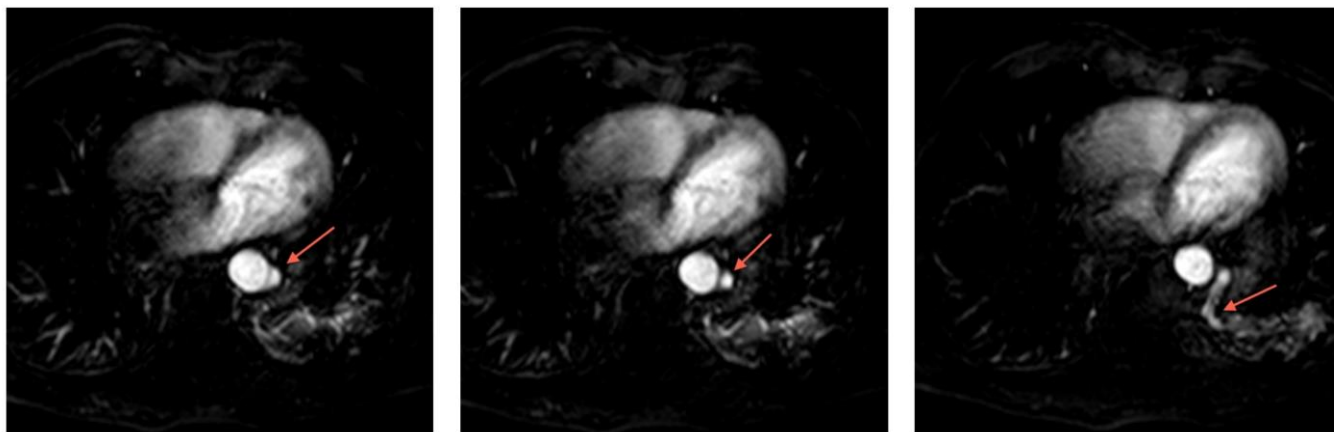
60 year old male with left lower lobe pulmonary sequestration. Findings: T1-post contrast axial MRI images demonstrate the abnormal vasculature (arrows) supplying the left lower lobe sequestration. Technique: MRI axial T1 THRIVE sequence 20 seconds post-contrast, TR 3.91, TE 1.84, FOV 375 mm, SENSE-XL-Torso coil, Magnevist 20 mL.
